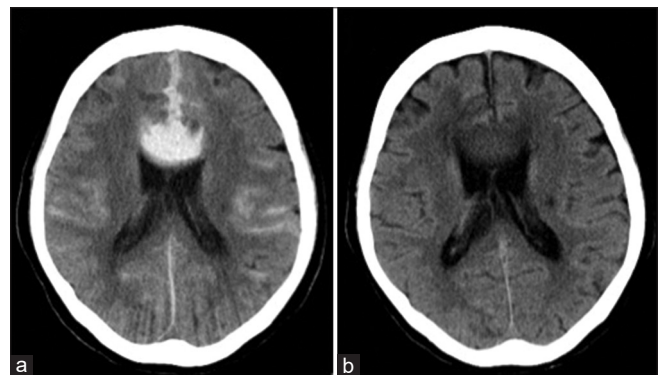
Postoperative computed tomography (CT) showing massive hematoma on the corpus callosum expanding into the cingulate gyrus (a). Forty-four days after subarachnoid hemorrhage onset, CT demonstrates that the hematoma on the corpus callosum has mostly disappeared (b).
